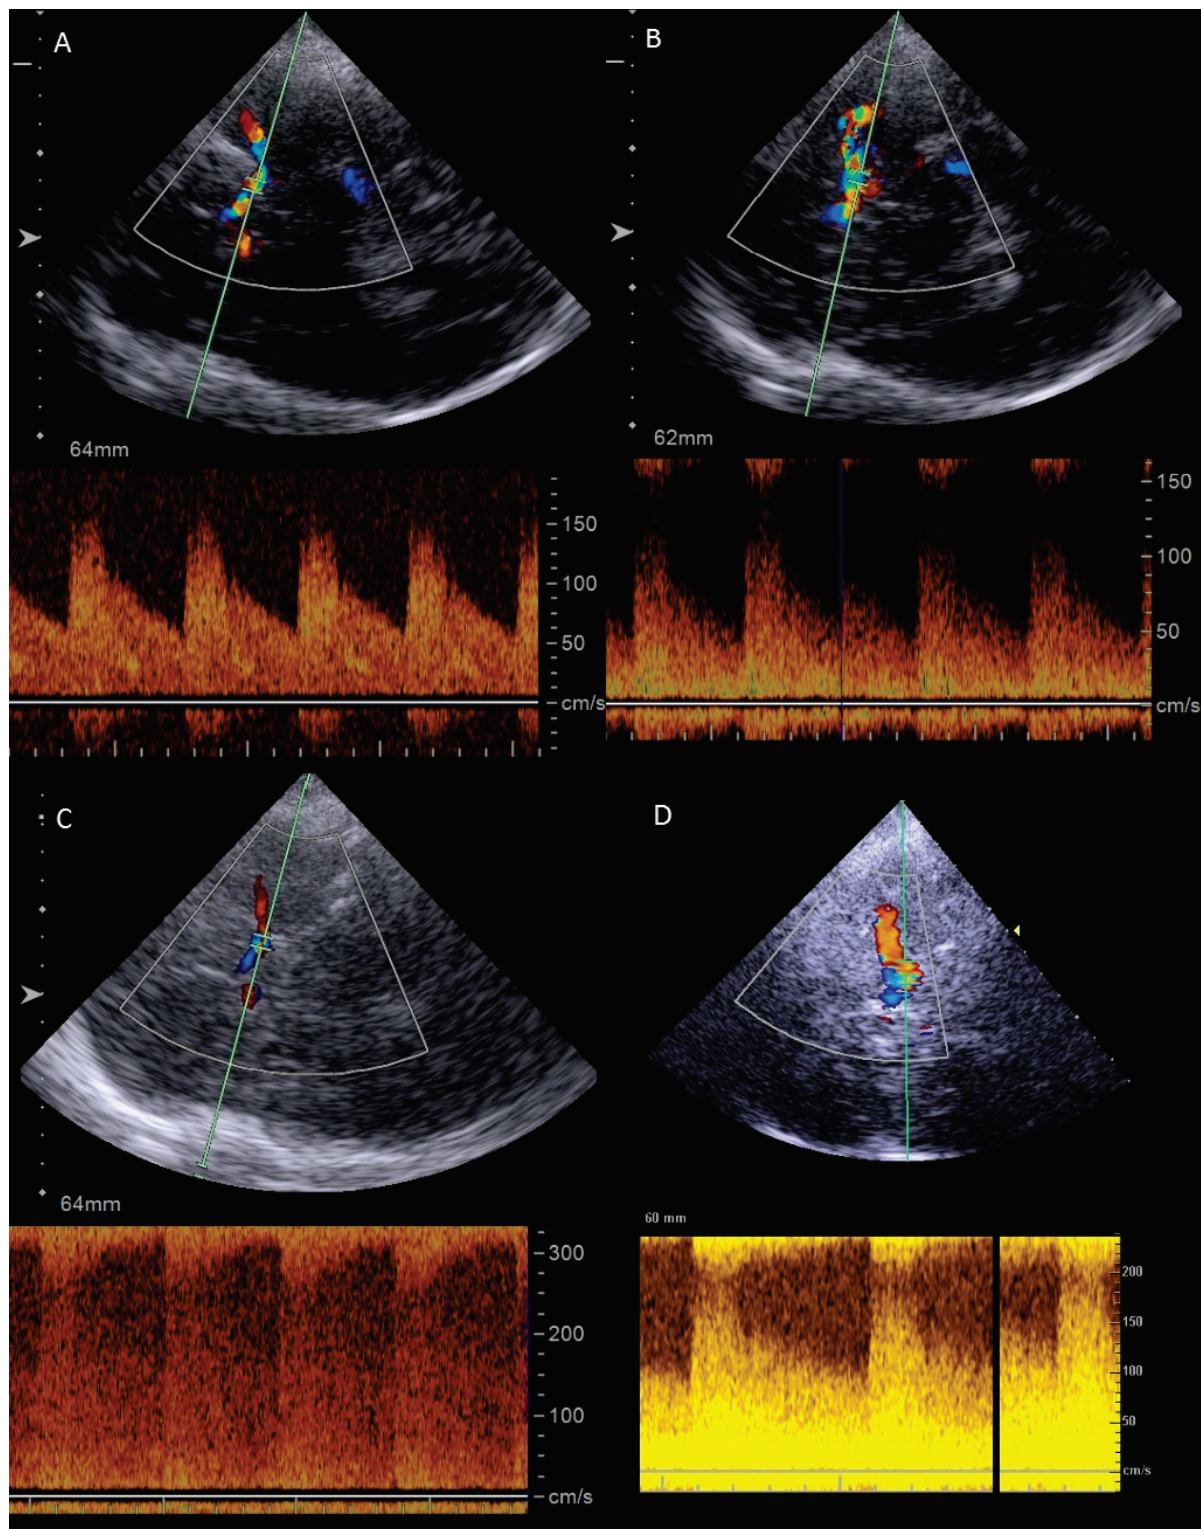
Exemplary case of a 64-year-old patient with GCA and transcranial sonographic images showing bilateral, distal ICA stenosis. (A,B) Baseline duplex sonography showing mildly increased blood flow velocity of the left (A) distal ICA and of the right (B) distal ICA. (C,D) Follow-up duplex sonography one month after baseline assessment showing highly increased blood flow velocity of the left (C) distal ICA and of the right (D) distal ICA.
